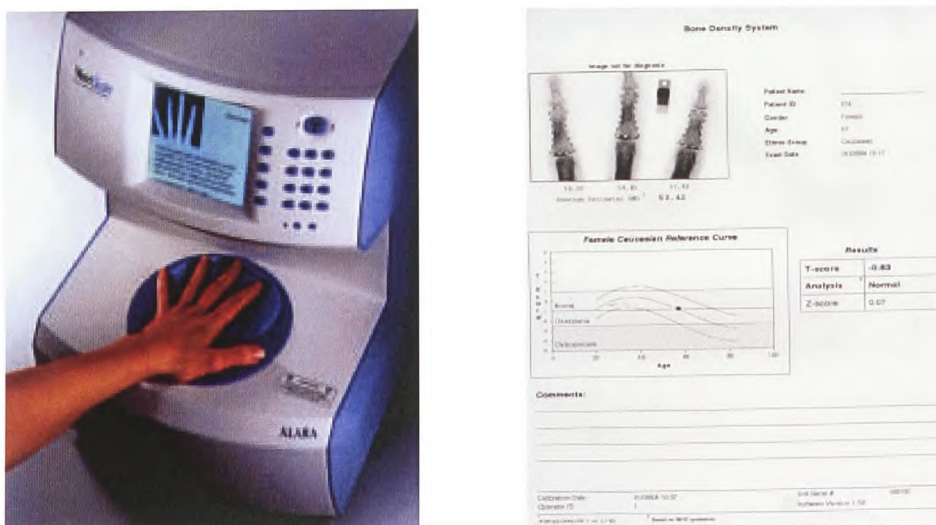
The Metriscan digital radiographic absorptiometer
